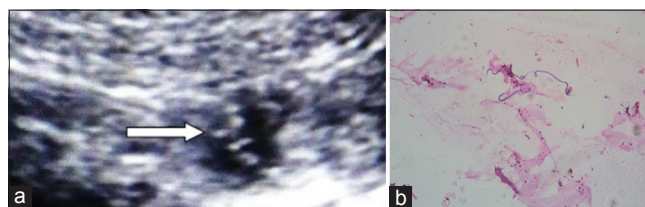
(a) Ultrasound of inguinal region showing well defined lobulated cystic lesion in left inguinal region with filarial dance sign, (b) cytology smear from inguinal swelling shows multiple microfilariae in a background of inflammatory cells
